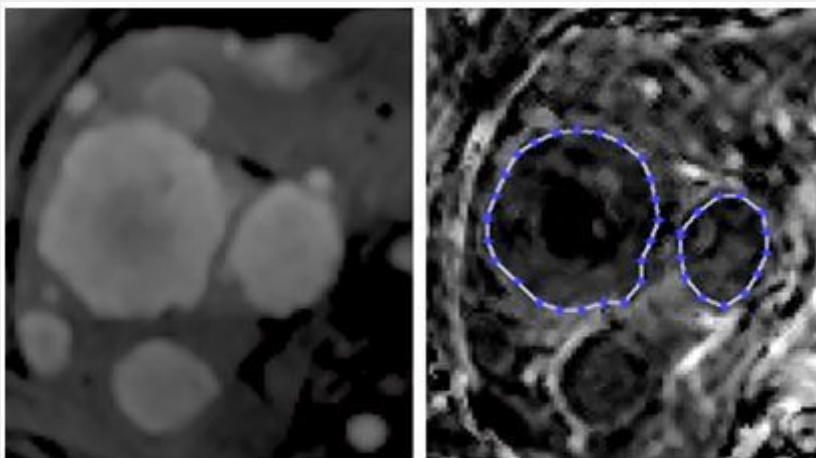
Left: Liver DWI (b=600) used to delineate all metastases (hyperintense regions) with a diameter > 2 cm. Right: Corresponding f -map where ROIs are superimposed and used to calculate median f of metastatic tissue.
